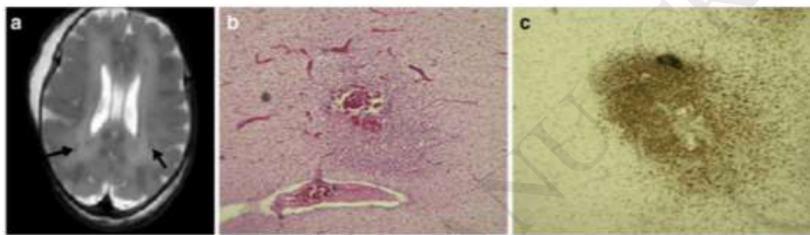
Post-mortem images of a preterm infant born at 34+6 weeks gestation, who died at 9 days of age. Hypotense focal lesions are observed at the T2-weighted MRI image and are mostly localized posteriorly (*arrows*) (a). These regions constitute perivascular lesions (b) which correspond to activated microglia aggregation (CD68 positive cells) (c). Adapted from (Rutherford et al., 2010).
